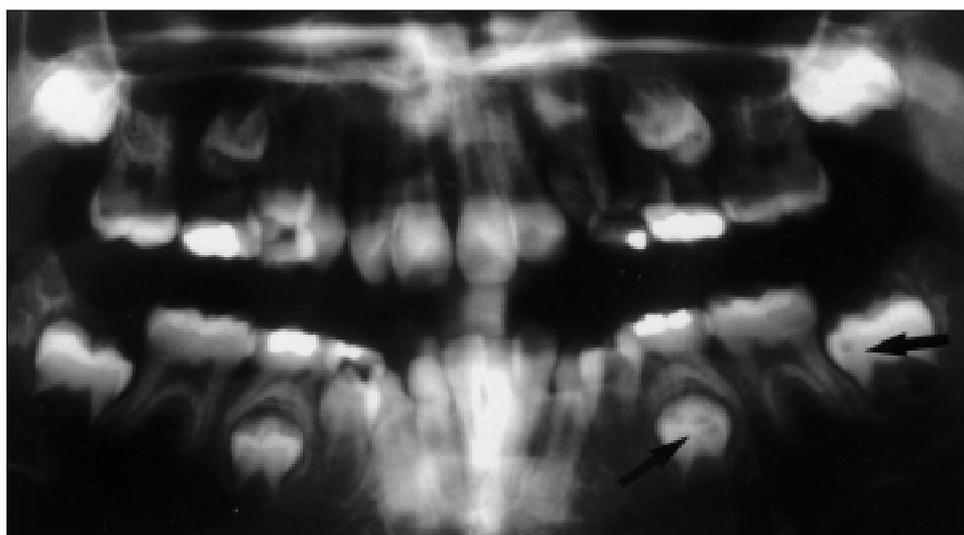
Orthopantomogram of the subject in Fig 1 at age 9 yrs, showing that radiolucencies (arrows) were already present within the crowns of the mandibular left second premolar and second molar. These are likely to be pre-eruptive intracoronal resorptive defects.
